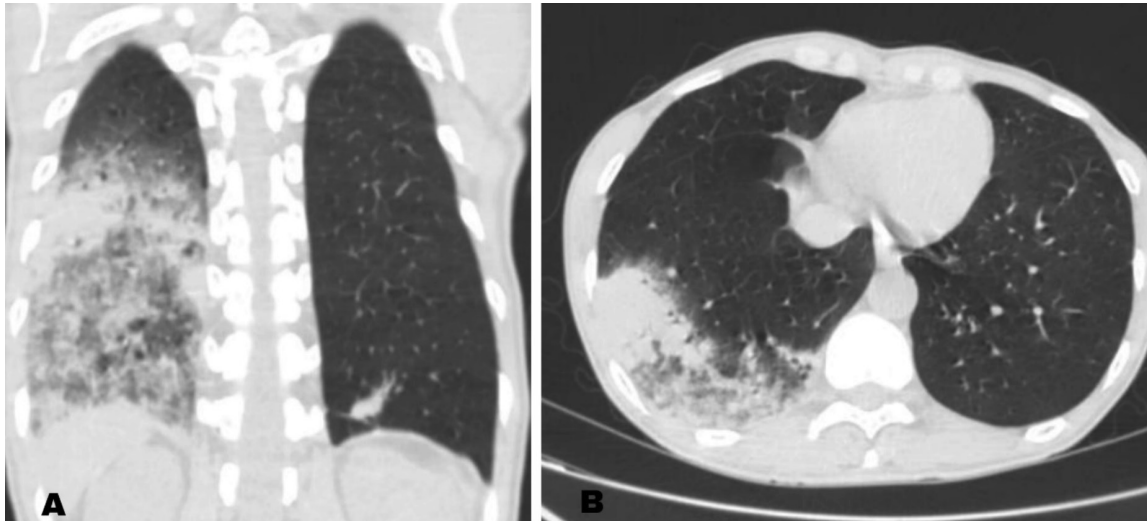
A, B) Coronal and axial non-contrast computed tomography images show diffuse pneumonic consolidation appearance in the lower lobe and the middle lobe of the right lung
